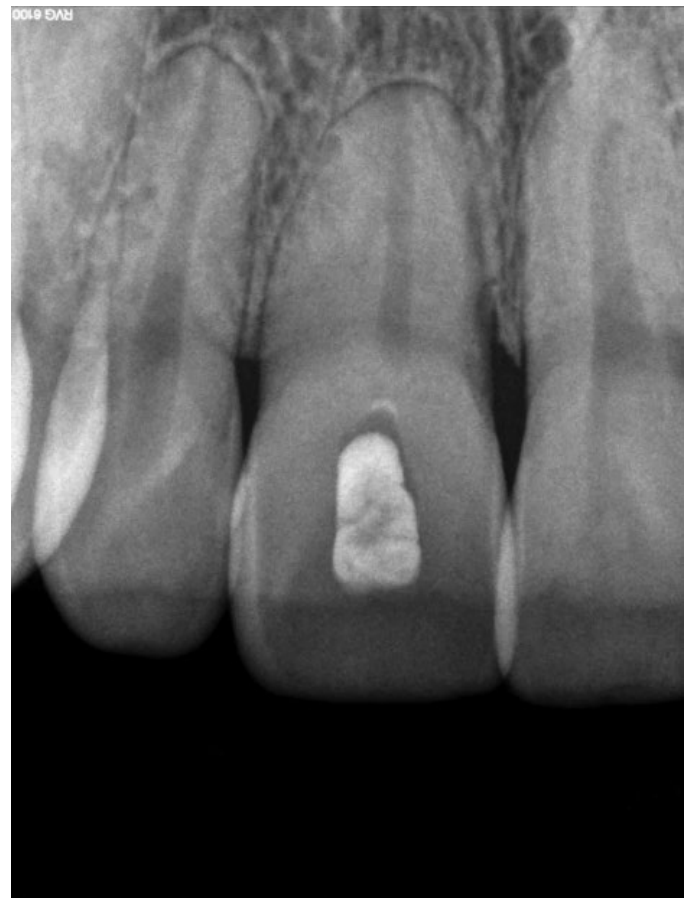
(I) Periapical image of walking bleach with small but accurately placed safe bleach barrier.
